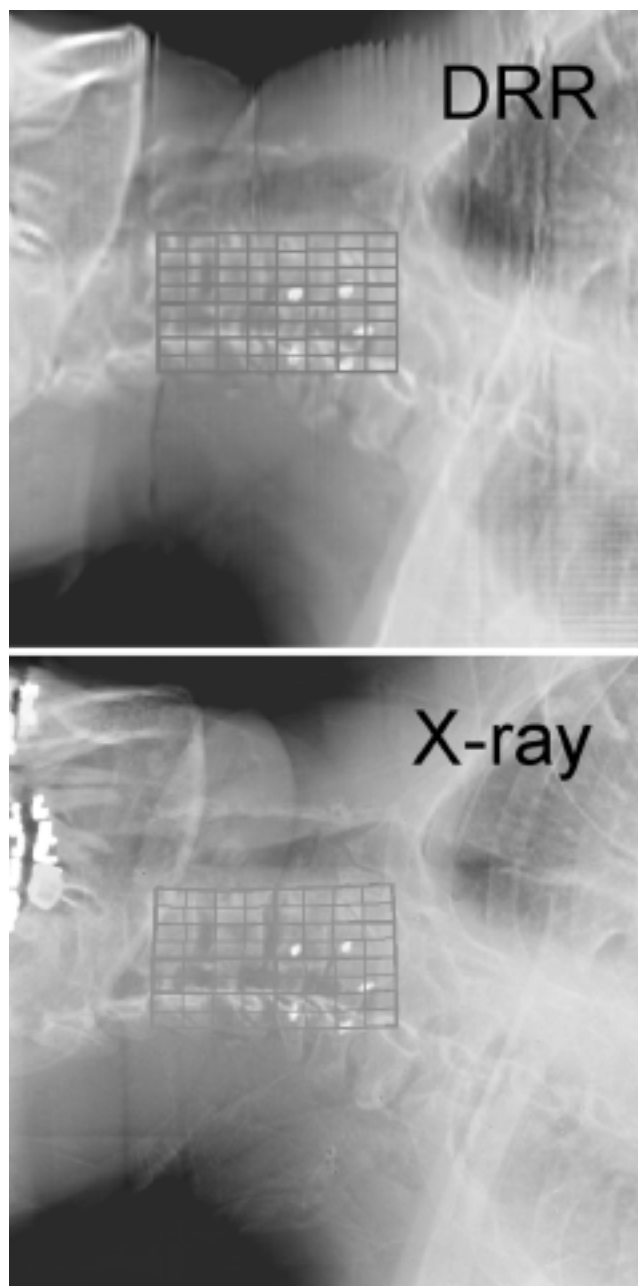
The hierarchical mesh tracking procedure. Registration is performed using a hierarchical mesh technique in which the calculation is made at a series of discrete points within the ROI. The process is iterative, with additional registration points added at each step to improve the spatial resolution of the result. This approach generates a deformable registration model, which can account for nonrigid changes in the patient posture between pre- and intratreatment imaging. The deformation is apparent in the mesh in the x-ray panel.
